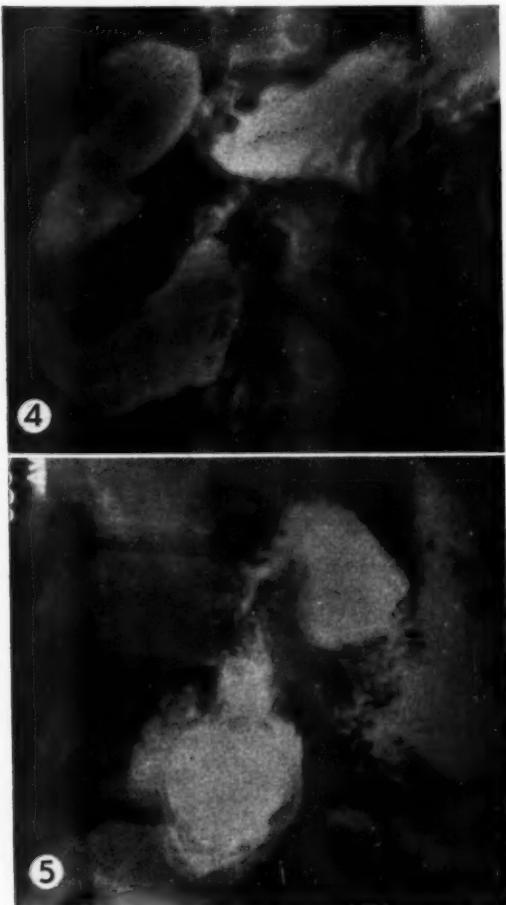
(above) Author's case. X-ray shows narrowing in the second portion of the duodenum. Otherwise there is insufficient evidence in this film to warrant the diagnosis of duodenal diaphragm.
